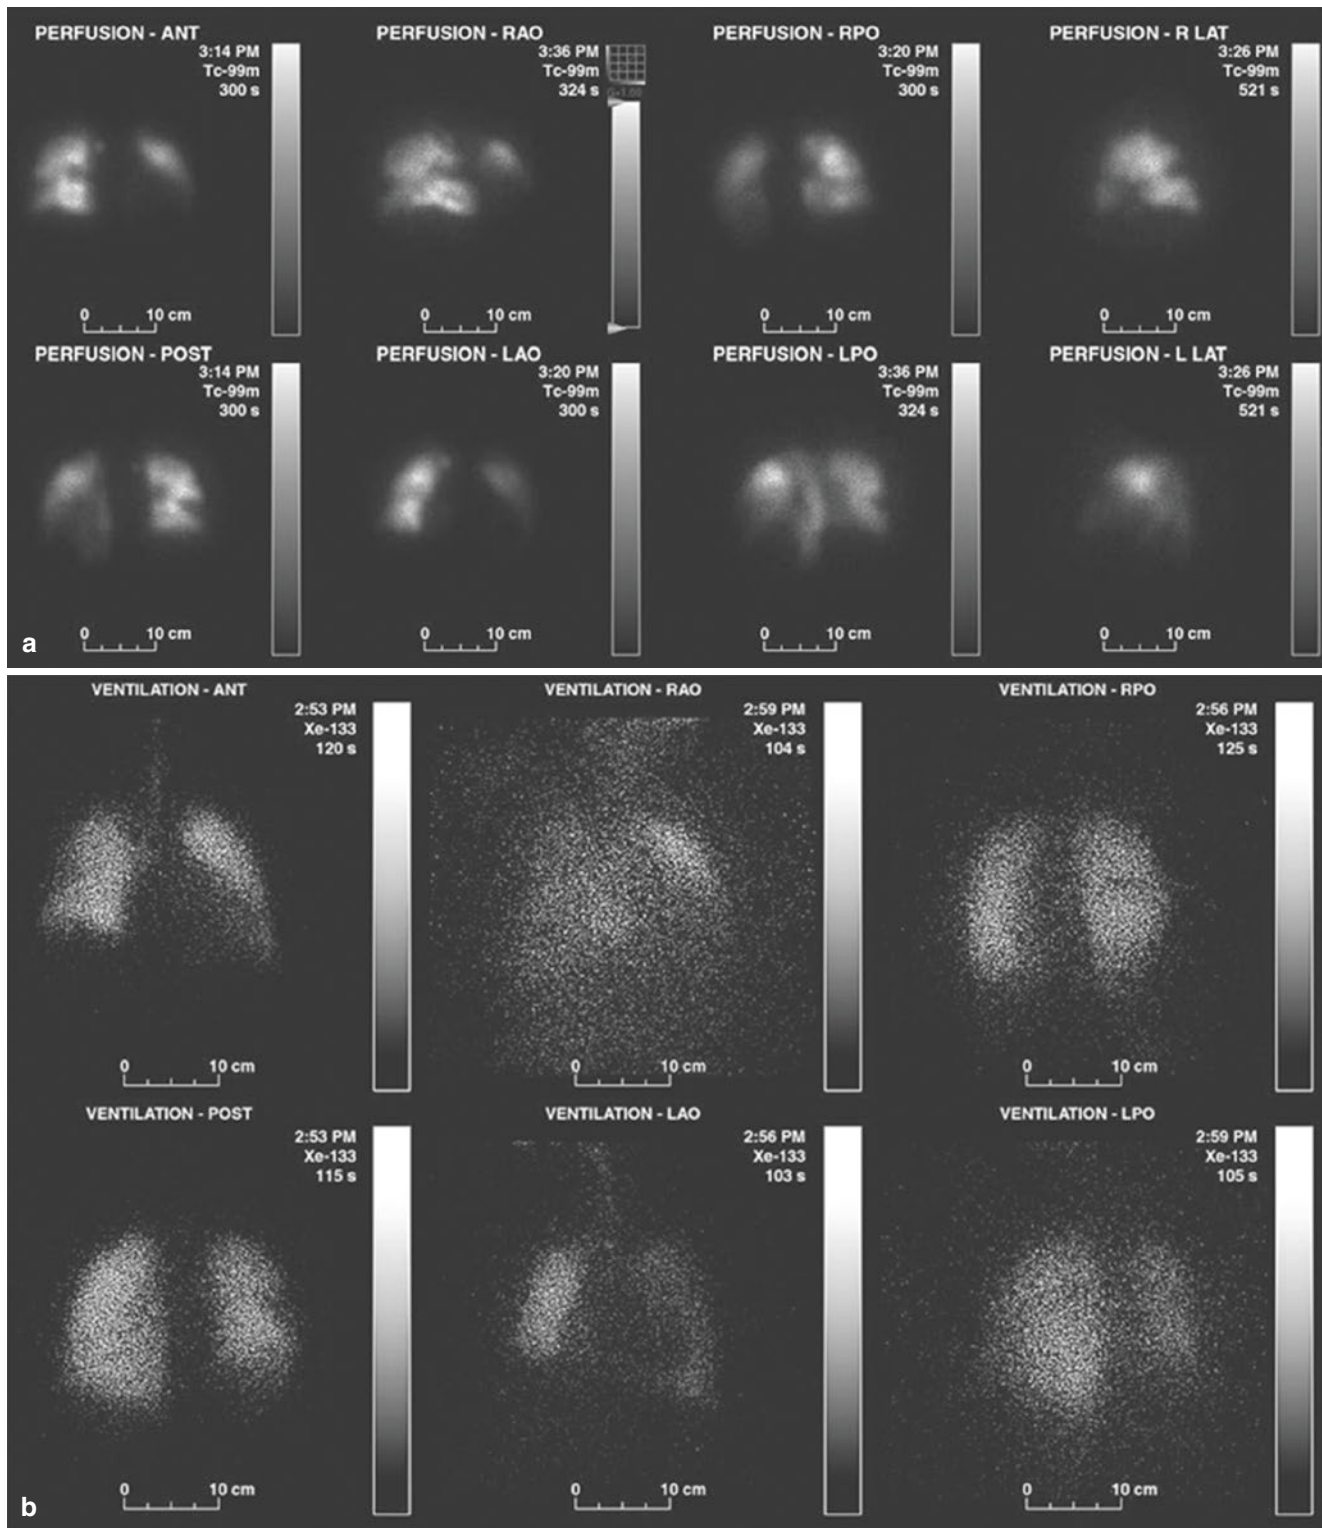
An 18-year-old female with a history of allergy to iodinated contrast presenting with chest pain. Chest radiograph (not shown) was normal. ANT anterior, RAO right anterior oblique, RPO right posterior oblique, R LAT right lateral, POST posterior, LAO left anterior oblique, LPO left posterior oblique, L LAT left lateral. (a) Planar perfusion images from a V/Q scan demonstrate multiple peripheral wedge-shaped
